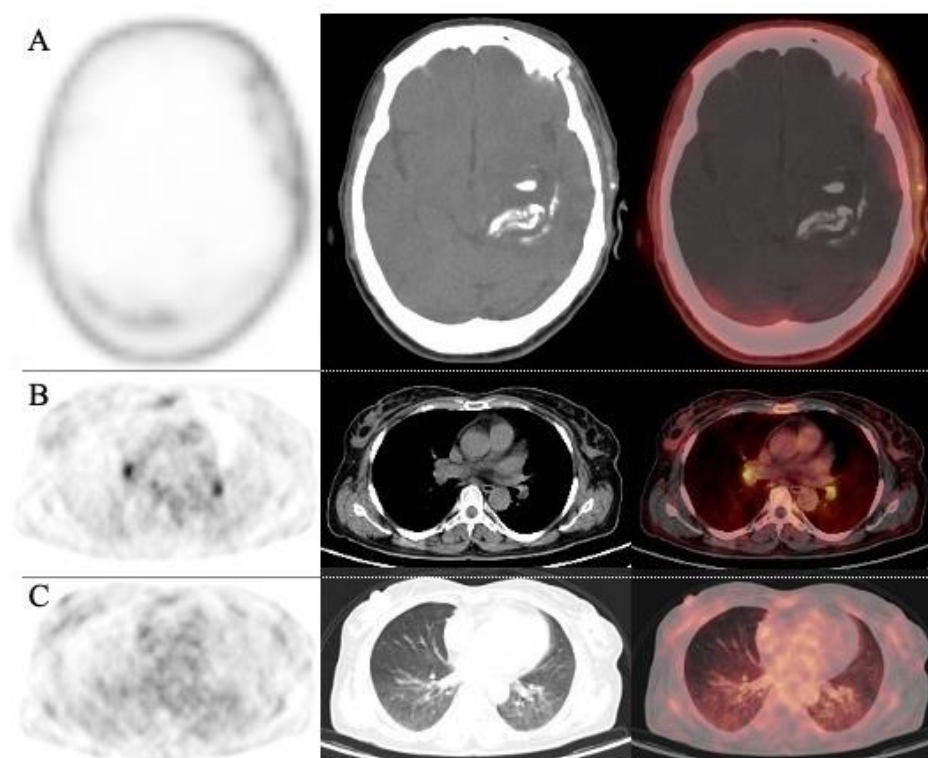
[⁶⁸Ga]Ga-Pentixafor PET/CT; A) Brain, No evidence of tumoral remnant, B) Pentixafor uptake (SUVmax 3.42) evident in the mediastinum corresponding to hilar lymph nodes, C) Mild diffuse uptake (SUVmax up to 2.60) in the basal and peripheral zones of both lungs with ground glass opacities (GGO) and consolidations
